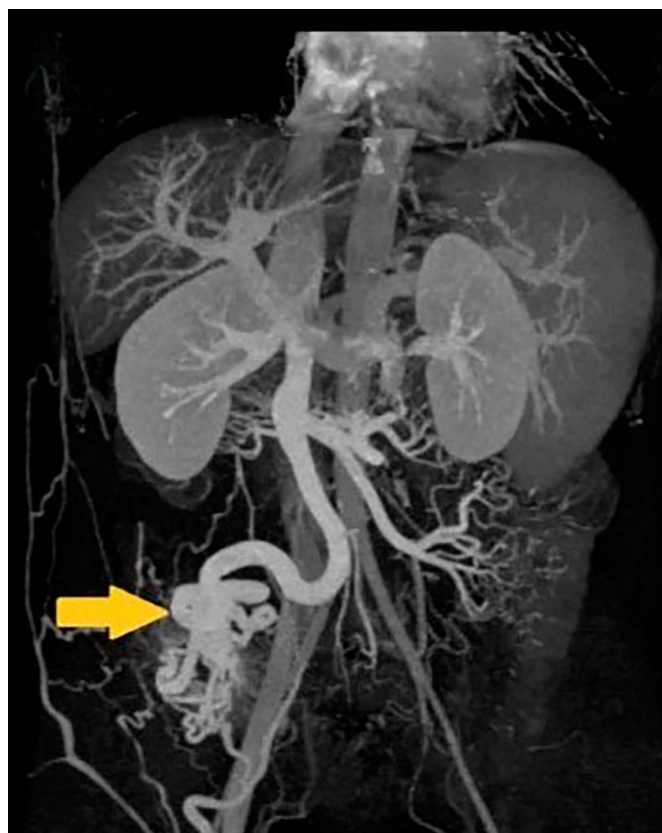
Contrast-enhanced computed tomography reconstruction in the portal phase at presentation showing the large peristomal varices (yellow arrow) communicating with the superior mesenteric vein and small connecting veins draining into the right iliac vein.
